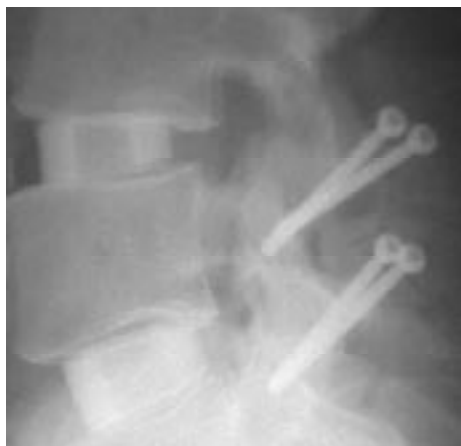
Lateral radiograph of two-level fusion with interbody graft and translaminar facet screws.
